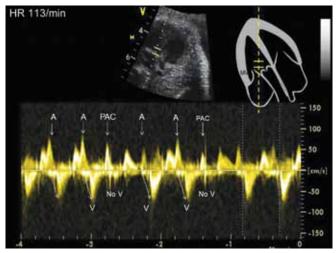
Blocked atrial ectopy is detected by simultaneous aortic and mitral Doppler interrogation
